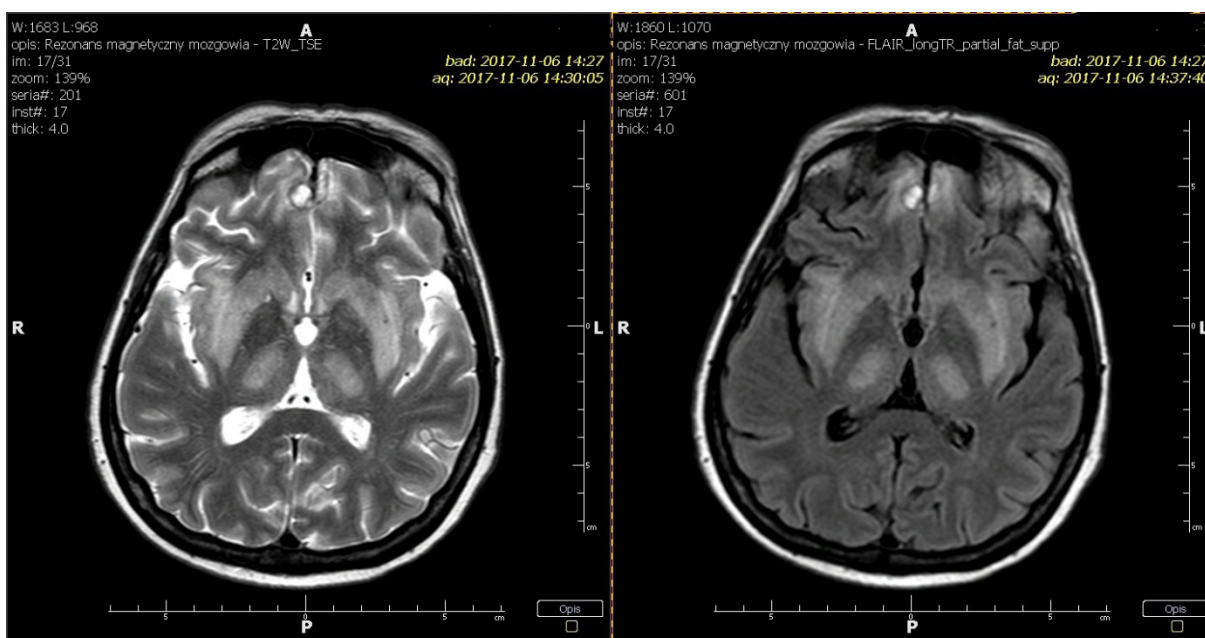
There are regions of increased signal in T2-weighted images and sequences SEQ Flair bilaterally in the subcortical nuclei, in thalami, centrally in the pons and there are smaller foci in the subcortical white matter of both hemispheres – most likely resembling acute osmotic demyelination
